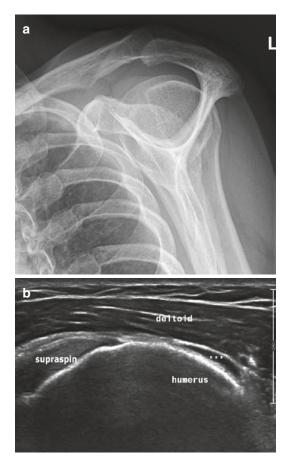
(a, b) Subacromion–subdeltoid bursitis above the supraspinatus tendon in a 50-year-old female. (a) Radiography; (b) ultrasound. Radiography shows an acromion type III, predisposing for impingement (a). Ultrasound reveals well-delineated anechoic structure with thin wall (++) (b)
